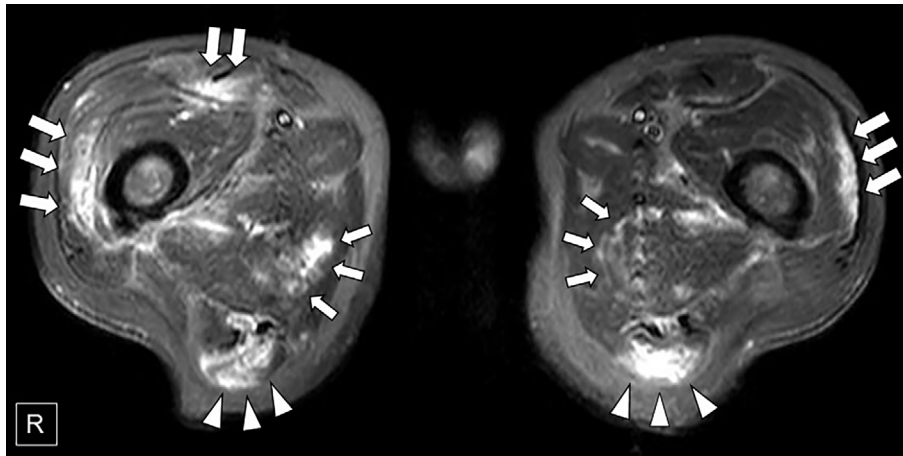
Myositis demonstrated by magnetic resonance imaging of the thigh muscles. Heterogeneous hyperintensities are evident in bilateral quadriceps femoris muscles (large arrows), adductor magnus muscles (small arrows), and hamstrings (arrowheads) on short-T1 inversion recovery images.
